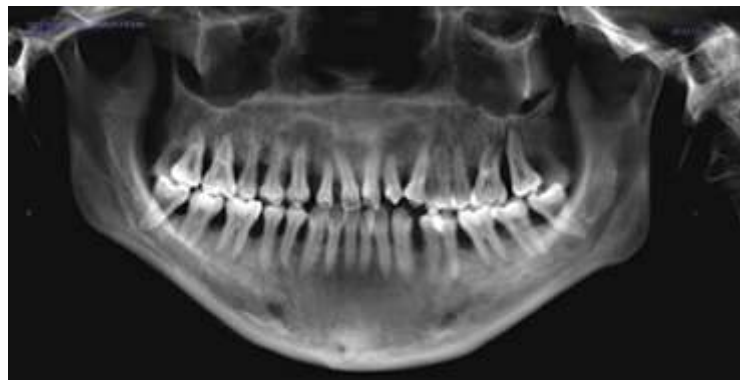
Panoramic X-ray, where we observe generalized moderate horizontal loss of bone crest height, and vertical loss in localized areas.
